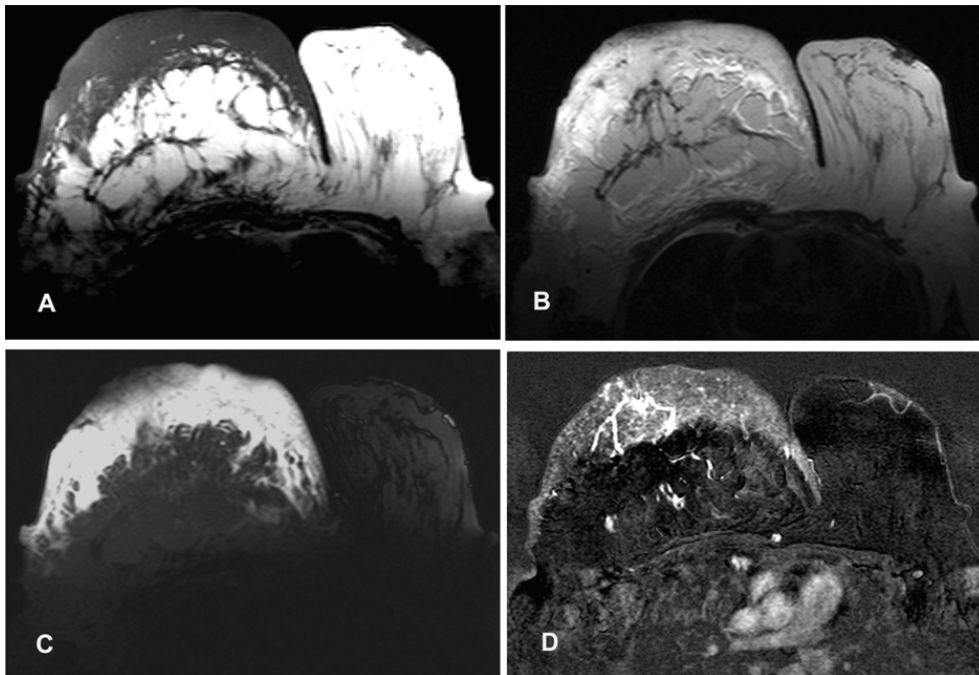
A) Axial turbo spin echo (TSE) T1-weighted (TR 550 msec; TE 11 msec; thickness 4 mm); B) TSE T2-weighted (TR 4000 msec; TE 120 msec; thickness 4 mm) and C) fat saturated TSE T2-weighted images were obtained. An axial 3-dimensional (3D) T1-weighted fast field echo (FFE) sequence (TR 6.5 msec; TE 3.2; flip angle 25; thickness 4 mm) was acquired before and after administration of intravenous paramagnetic contrast media. 3D T1-weighted postcontrast sequence was repeated five more times and post-processing of images included subtraction of postcontrast series from precontrast one (D) and calculation of time-signal intensity curves. A) Diffuse areas of low signal intensity on T1-weighted and B, C) widespread hyperintense areas on T2-weighted images suggesting edema were seen. D) These edematous areas demonstrated marked contrast enhancement. However, no focal abnormal signal changes suggesting malignancy was observed.
